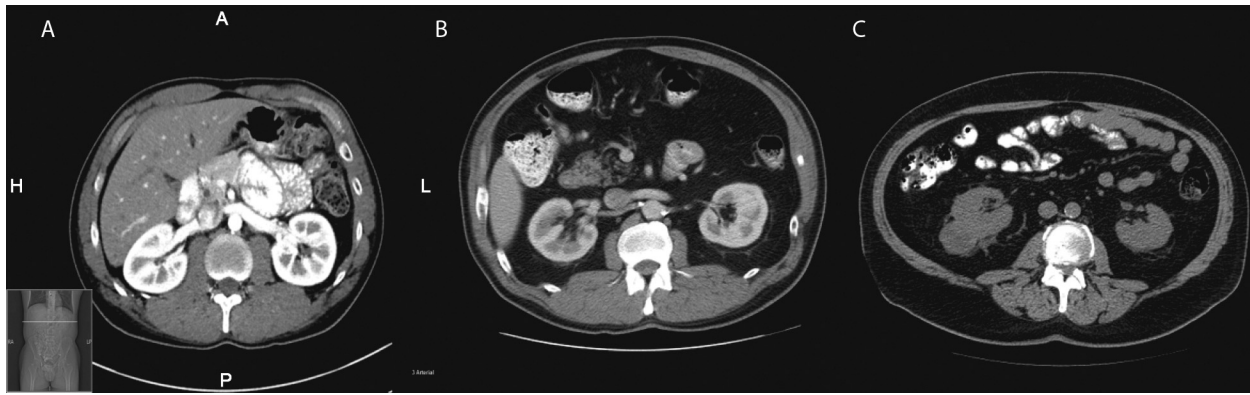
Grading of perinephric stranding. (A) None: 0 points. The fat around the kidney demonstrates no stranding. On this computed tomography image, the tissue surrounding the kidney is completely black. (B) Mild/moderate (type 1): 2 points. The fat around the kidney has some image-dense stranding present but no thick bars of inflammation. (C) Severe stranding (type 2): 3 points. Image shows severe stranding around the kidney with thick image-dense bars of inflammation.
